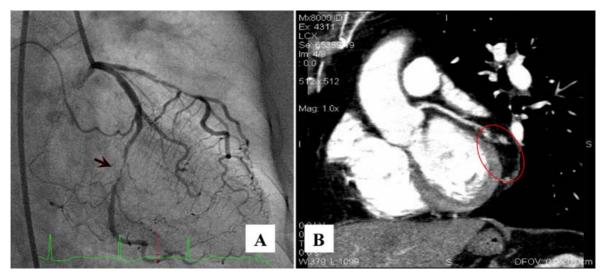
A shows severe stenosis at the mid LCx on CAG but cannot demonstrate this segment of the vessel on CTA, due to small size
